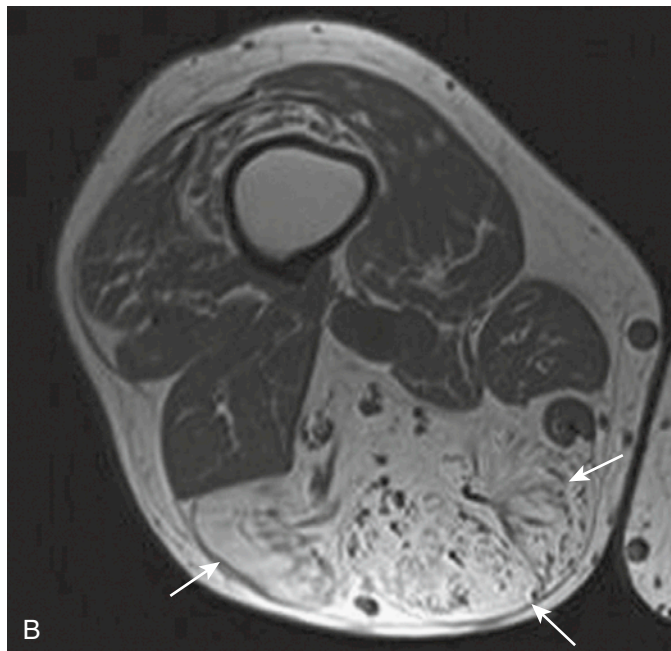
A, Patient with posterior thigh swelling. Longitudinal panoramic ultrasound shows a diffuse echogenic fatty change within the muscles, which suggests an intramuscular lipoma. B, Axial, T1-weighted MRI shows replacement of the posterior compartment muscles by fat (*arrows*). This was denervation atrophy and pseudohypertrophy from fat deposition due to previous spinal surgery.
